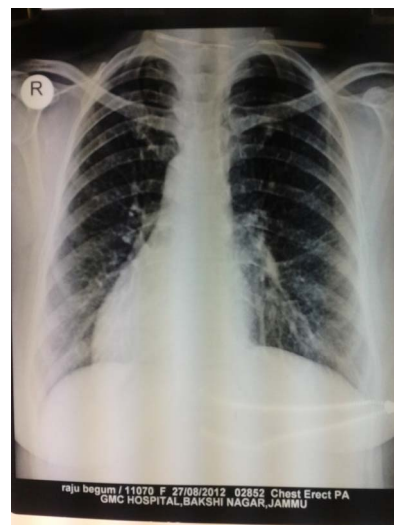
Chest X-ray showing dextrocardia consistent with situs inversus.
